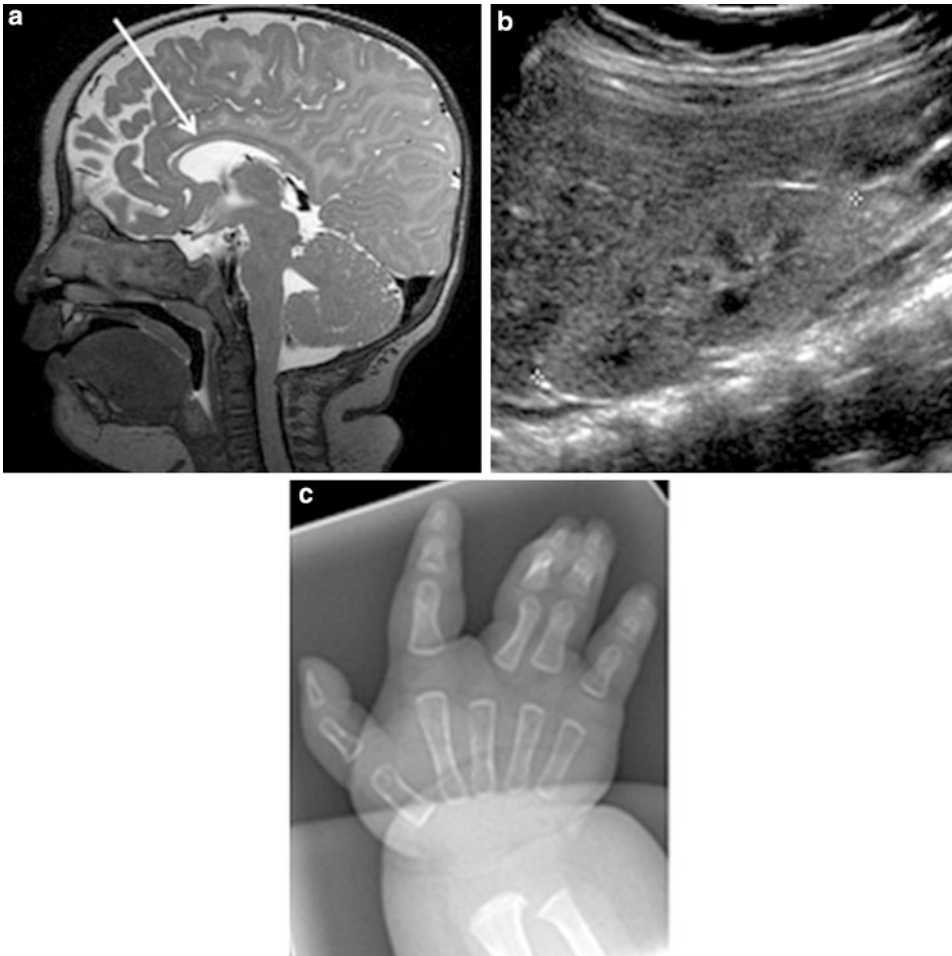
(a–c) The 2-year-old female was diagnosed to have Wolf–Hirschhorn syndrome based on chromosome 4p deletion noted on amniocentesis. Clinical features are characterized by secundum atrial septal defect with pulmonary stenosis, global developmental delay, seizure disorder, tethered cord status post repair at 1 year of age, neurogenic bladder, vesicoureteral reflux, chronic kidney disease secondary to renal dysplasia, gastroesophageal reflux status post repair Nissen fundoplication, cortical visual impairment, right hand syndactyly, chronic lung disease, and precocious puberty. Immunoglobulin study revealed very low IgG (185), normal IgA (38), and low IgM (13). MRI of the brain at 6 month of age (a) demonstrated global
